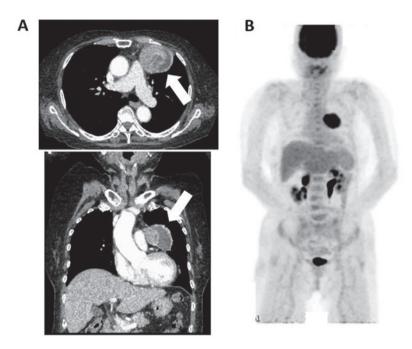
Clinical presentation of the tumor. (A) CT scan presenting a 70 mm mass in the left anterior mediastinum. (B) Positron emission tomography-CT scan revealing strong fluorodeoxyglucose accumulation in the tumor (maximum standardized uptake value, 10.9). White arrows indicate the tumor location.
